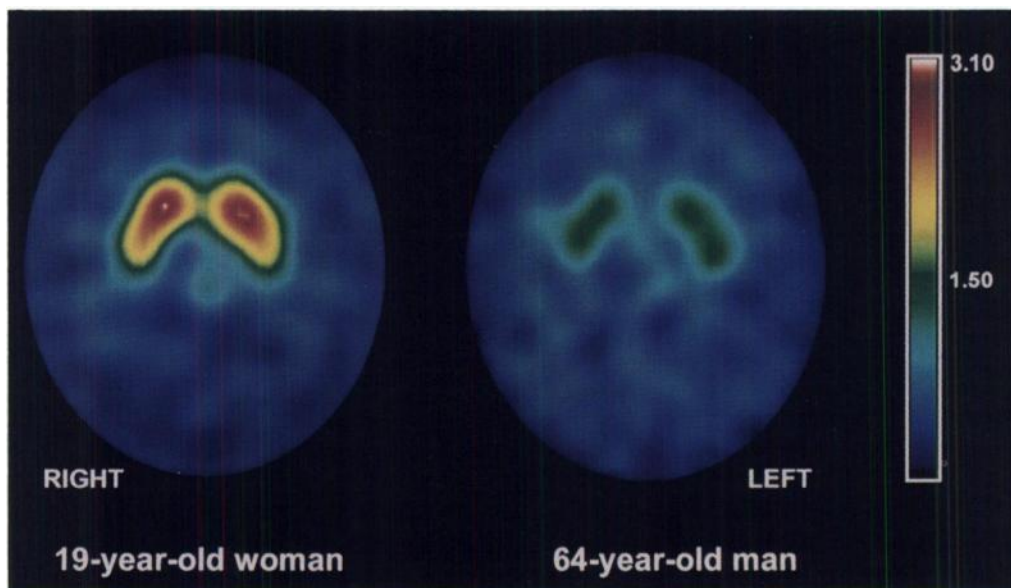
Transaxial IBF SPECT images obtained 160–170 min postinjection at the level of the striatum of 19-yr-old woman and 64-yr-old man. Relative iodobenzofuran uptake in the striatum is markedly higher for younger subject (left) than for older subject (right). Image intensity has been adjusted so that striatal activity roughly reflects relative differences in mean basal ganglia Rv values between the two subjects (left image Rv = 3.06, right image Rv = 1.49), although these images are not a parametric map.
